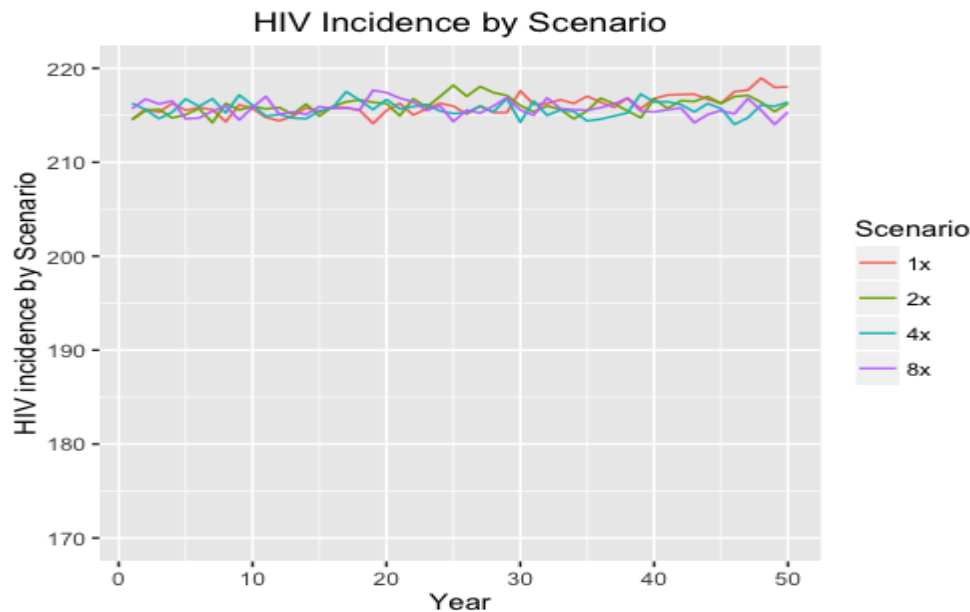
presents HIV incidence under the increased NG/CT screening strategy for 15,000 MSM for each year by each scenario.
